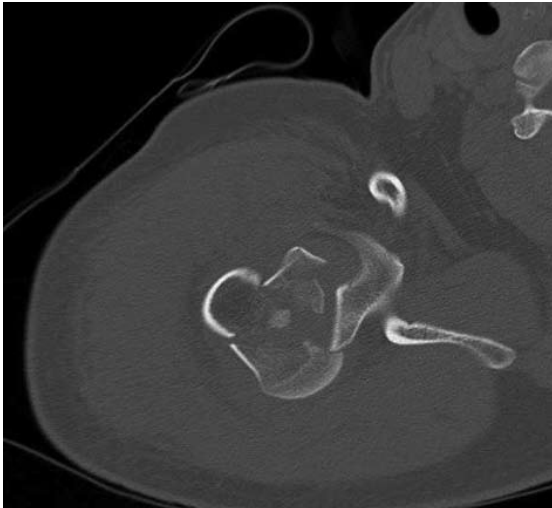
CT image shows a four-part humeral head fracture-dislocation.
